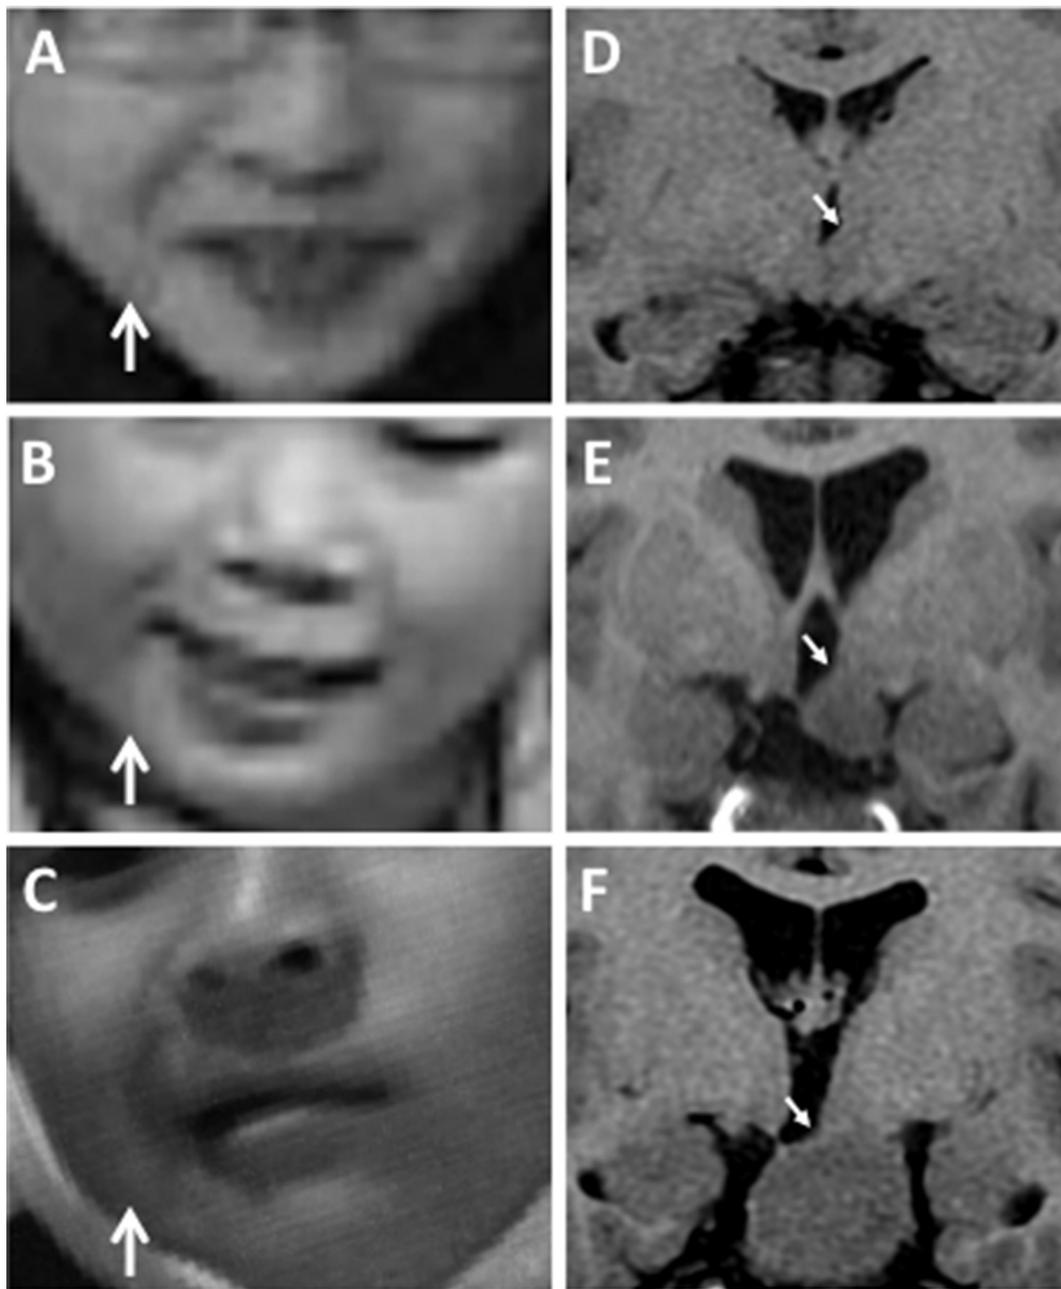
Asymmetric GS and HH attachment shown in three representative cases. A–C) Magnified pictures of lower-half faces exhibiting asymmetric GS (arrows) on the right side, recorded by respective long-term video-EEG monitoring in three representative cases. D–F) The attachment of HH (arrows) on coronal MRI was recognized on the side contralateral to asymmetric GS in each case.
